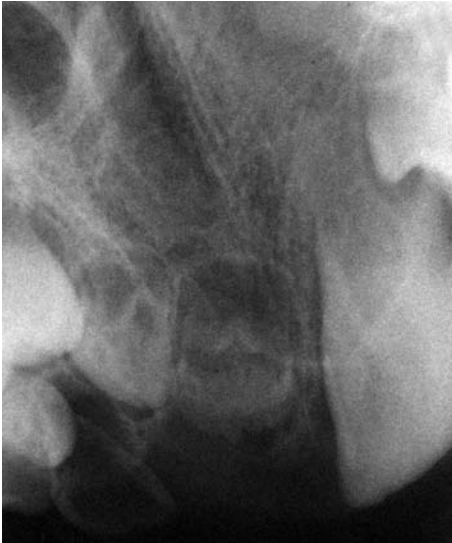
Periapical radiograph showing the characteristically ghost-like appearance of regional odontodysplasia.
